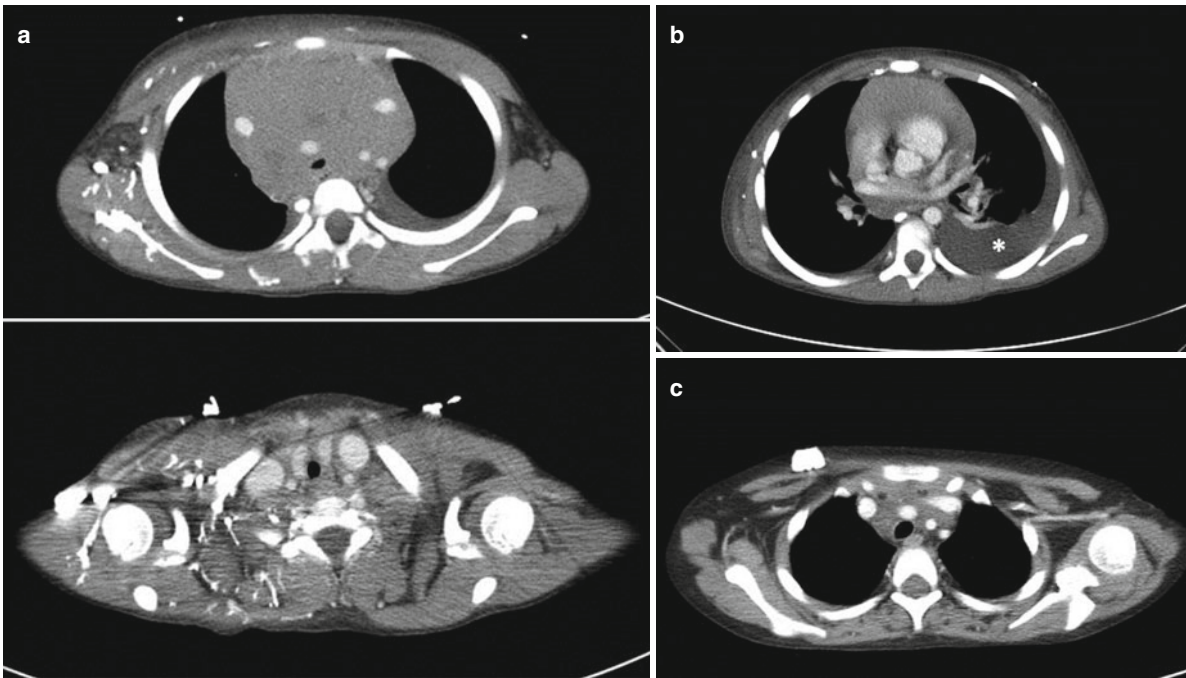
(a) CT scan of a 7 year old boy presenting with facial swelling, chest wall spider angiomas, dyspnea and impending respiratory failure. Patient received intravenous methylprednisone and two sessions of radiation therapy. Note the collateral vessels indicative of SVC obstruction consistent with SVC syndrome. Tracheal cross section is 16 mm², 23 % of predicted value for age. (b) A pleural effusion developed 3 days later (*), thoracentesis was performed under local anesthesia, with child life specialist to distract the patient. However the pleural
